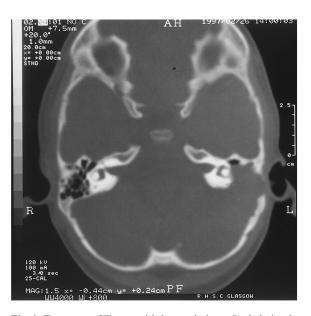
Transverse CT scan with bone windows. Lytic lesion in the left petrous temporal bone with extension into the lateral semi-circular canal.
